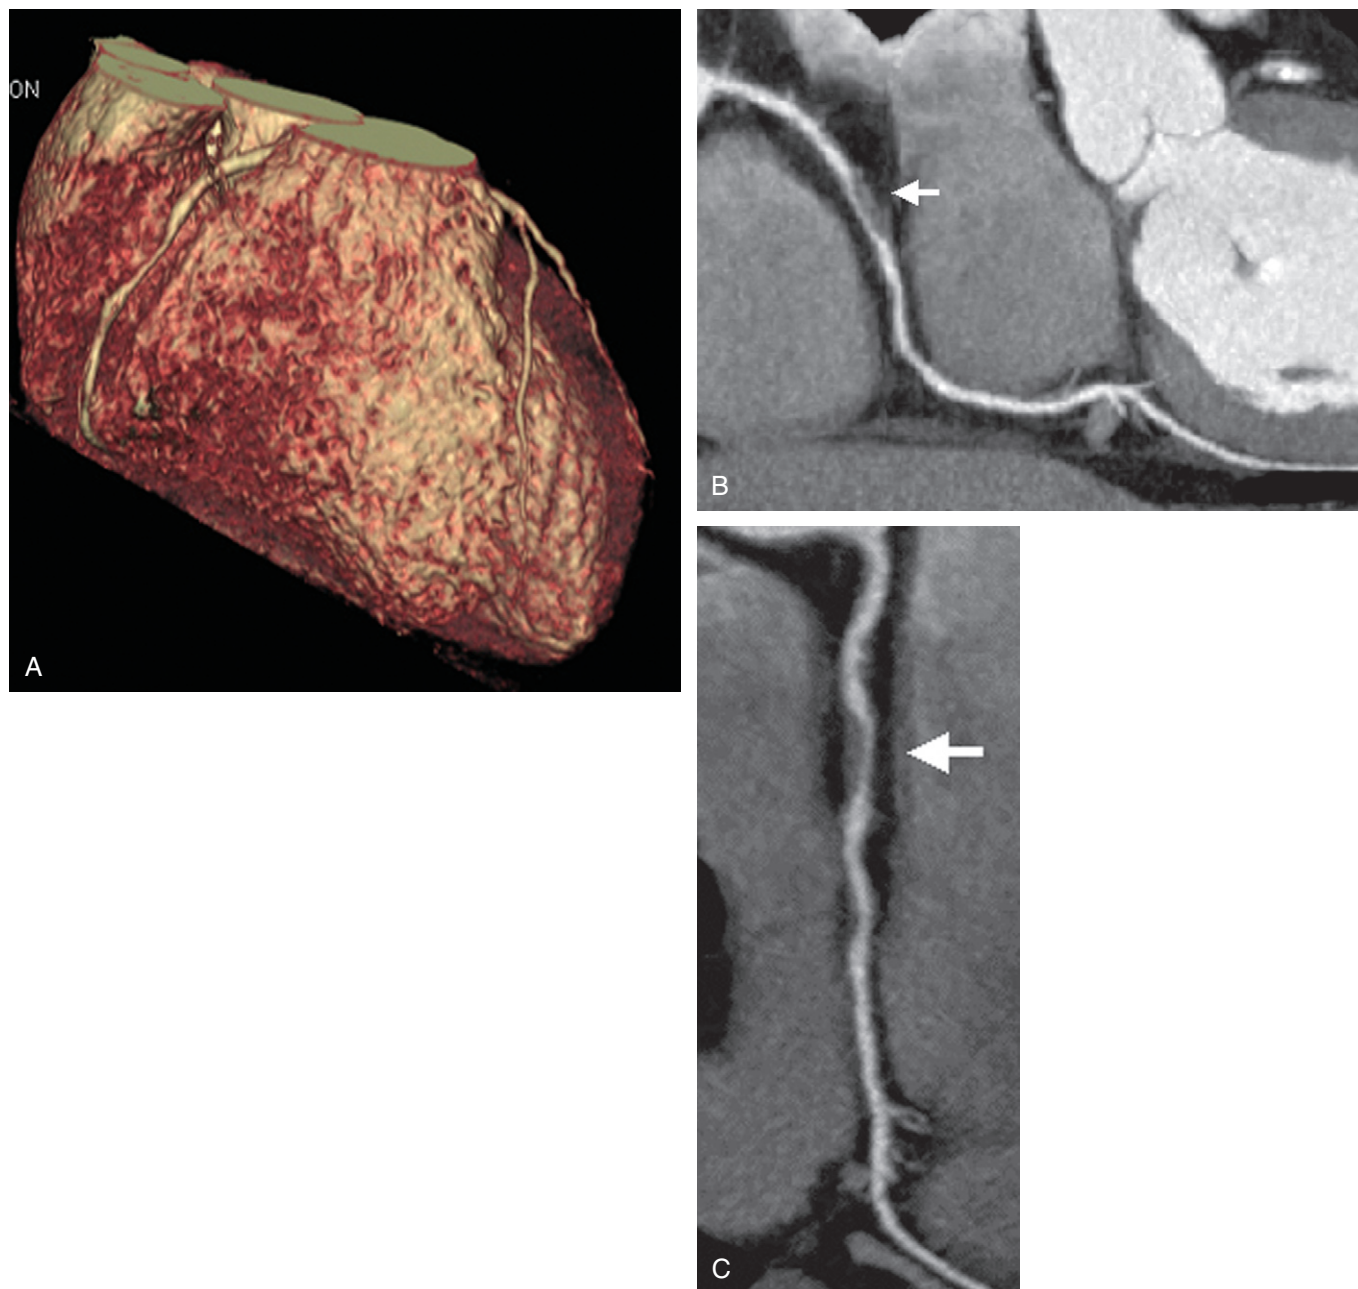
A, volume rendered image RCA; B, C, curved multiplanar reconstructions of RCA with severe non-calcific plaque. Dual-source CT coronary angiography demonstrating a noncalcified severe lesion with outward remodeling (B, C, arrows) of the RCA. RCA, right coronary artery.
